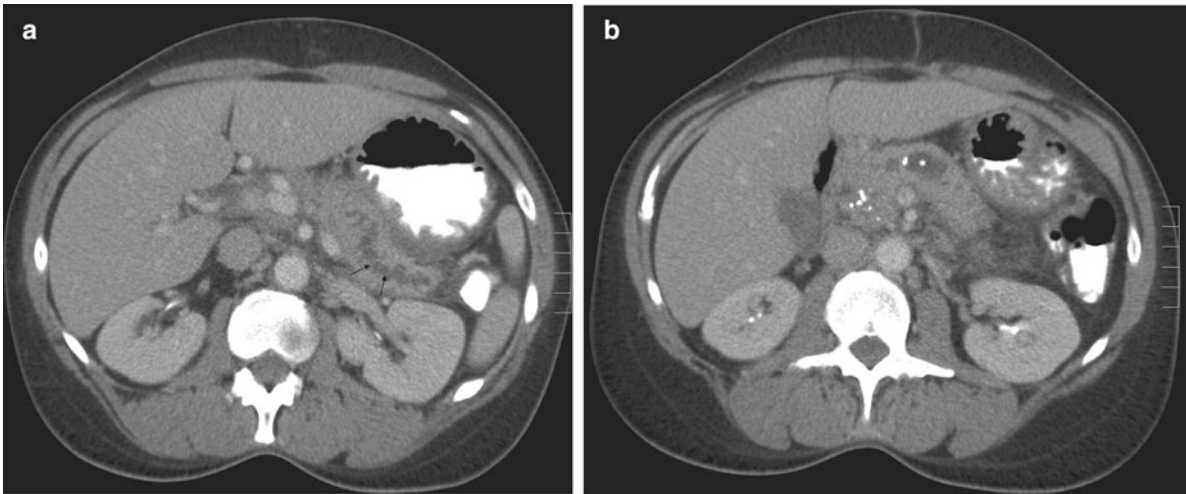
A 66-year-old man with long standing alcohol history presents with weight loss, postprandial abdominal pain that radiates to the back that is worse with meals. He has six to eight bowel movements a day usually following a meal. (a) Axial oral and intravenous contrast enhanced CT image through the level of the pancreas shows irregularly
